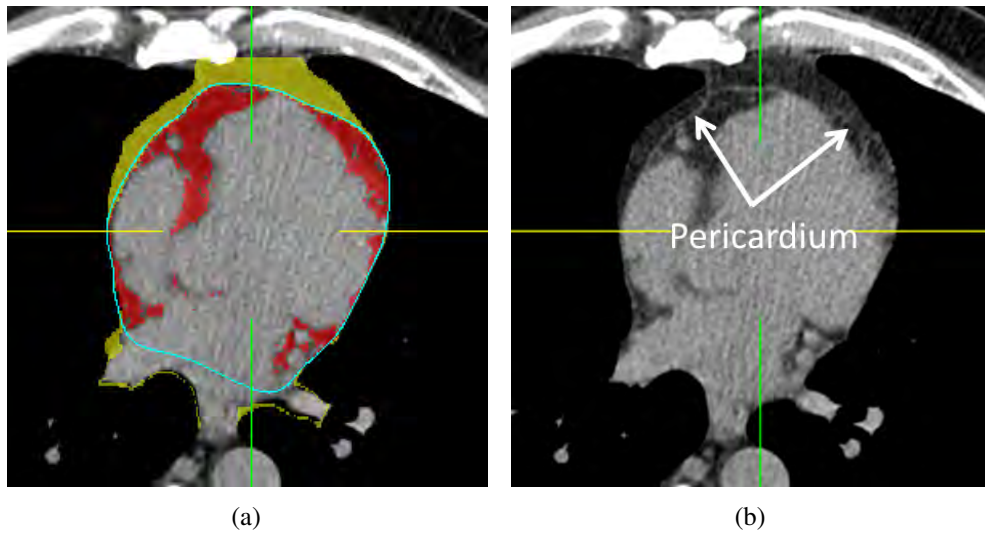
Epicardial fat (red), thoracic fat (red and yellow), and pericardium (blue line) in a non-contrast CT transverse slice (a). Arrows (b) indicate the pericardium in the original image.*
